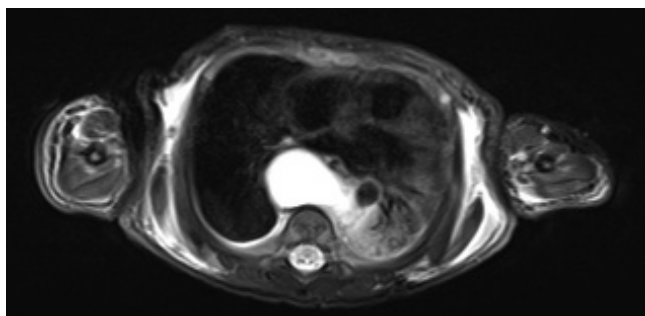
Transverse section of a T2-weighted MRI scan of the patient in Figure 45.5. Again the oesophagus can be seen pushed to the left.
